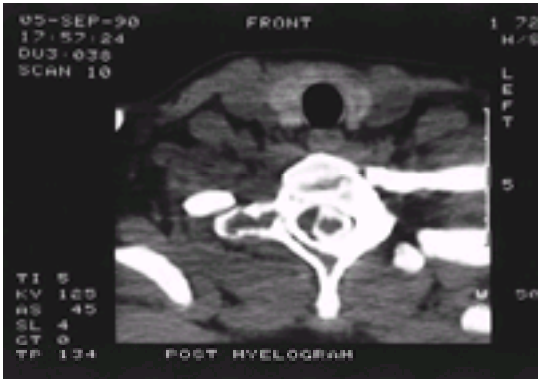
CT scan after a myelogram to show contrast in the subarachnoid space (white) and an extradural lesion compressing the theca from the right. The transverse process is expanded by tumour. The appearances are typical of a lymphoma. CT-guided biopsy avoids open surgery.
